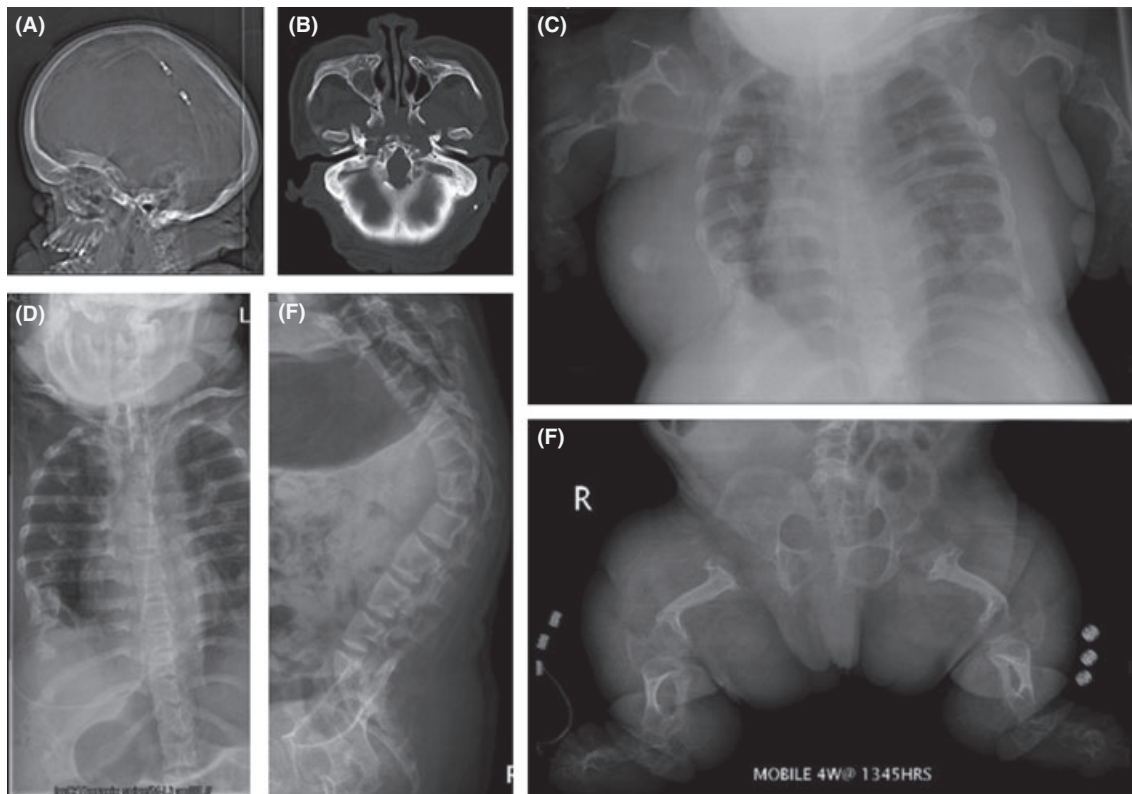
Radiographs: (A) Lateral skull demonstrating macrocephaly, midface hypoplasia, shunt placement, and excess skin; (B) Computed tomography at 22 years demonstrating craniocervical spinal stenosis; (C) Chest film including upper limbs – long bones are extremely short and thin with splayed metaphyses; (D) Chest film demonstrating small chest due to short ribs (E) Lateral film at 26 years showing tall vertebral bodies in comparison to depth, short pedicles, and a prominent kyphosis; (F) At 26 years of age, there is osteopenia and a gracile appearance of the pubic bones. The femurs measure 8 cm and the tibiae measure 5.7 cm.
